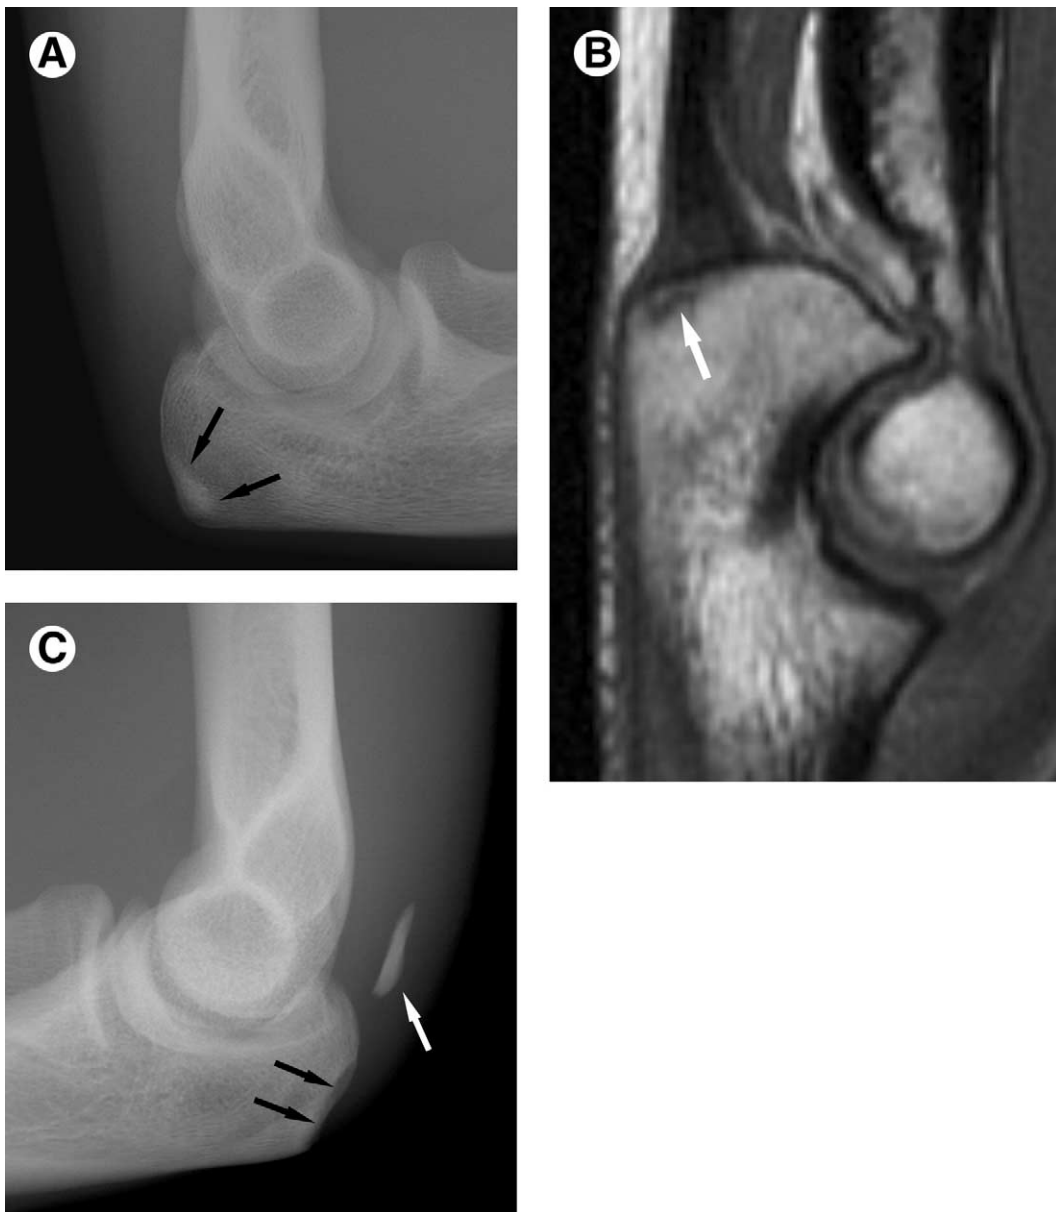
Posterior injuries of the young athlete. (A) Lateral view shows focal linear area of sclerosis along posterior border of olecranon process (arrows) in young throwing athlete with posterior pain. (B) Sagittal T1-weighted MR image confirms stress fracture in this location. Small serpentine hypointense line (arrow) interrupts hyperintense bone marrow in region of fracture. (C) Lateral radiograph in different young pitcher demonstrates displaced avulsion fracture (white arrow) of olecranon process (black arrows). Complete fracture is not uncommon at site of chronic stress change in young athletes.
